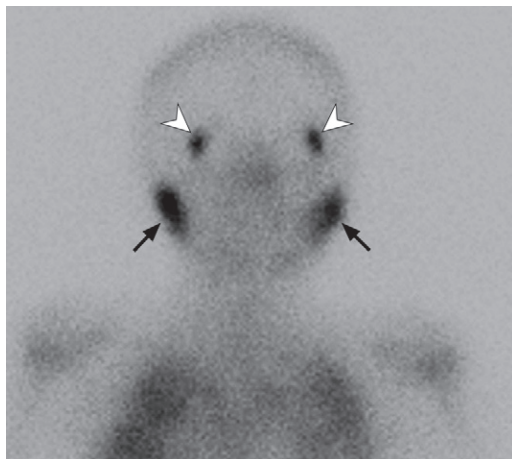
Lacrimal gland and parotid involvement in a 13-year-old adolescent girl. ^{67}Ga scintigram shows the “panda sign,” increased uptake of radiotracer in the lacrimal (arrowheads) and parotid glands (arrows), with physiologic accumulation in the nasopharynx.
